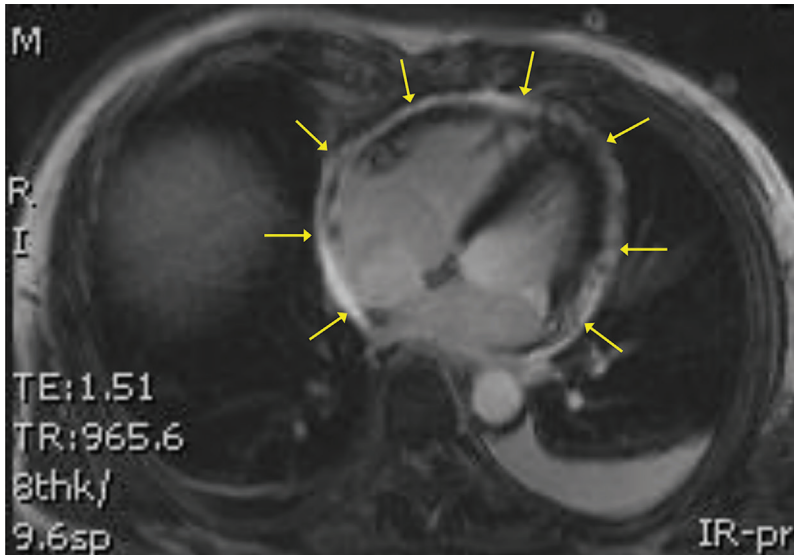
Cardiac magnetic resonance imaging (CMR) - a sequence for late gadolinium enhancement (LGE) for a newly diagnosed constrictive pericarditis. Yellow arrows indicate late gadolinium enhancement suggesting an active pericardial inflammation.
